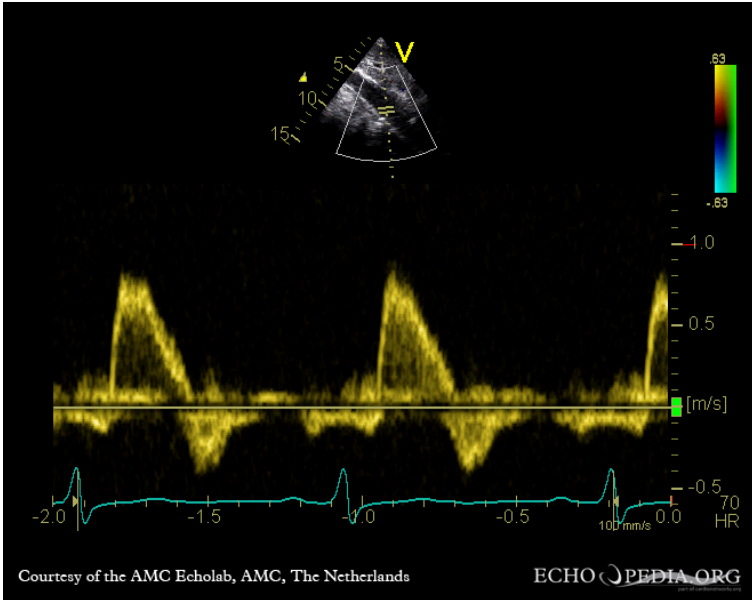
Echocardiogram showing dilated ascending aorta with severe aortic regurgitation. [Dilated ascending aorta, severe aortic regurgitation E00449 \(CardioNetworks ECHOpedia\)](#) by CardioNetworks licensed under [CC BY-SA 3.0](#)
